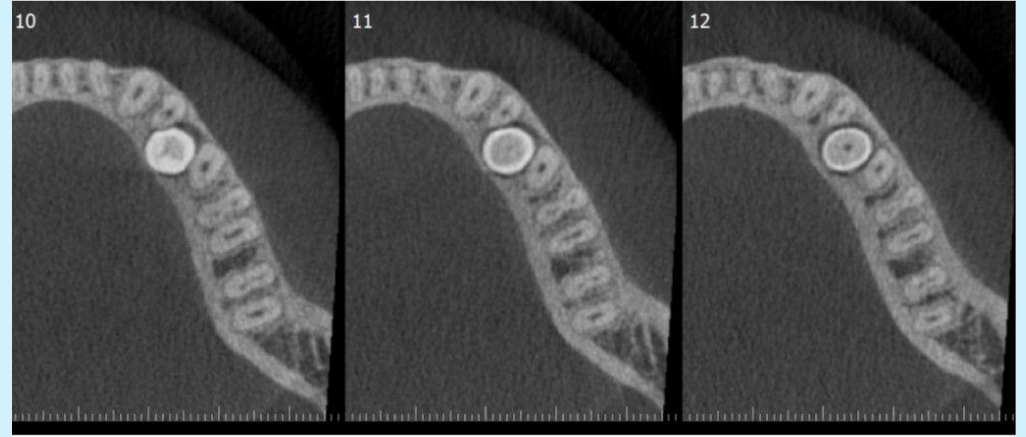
CBCT image, axial slices
